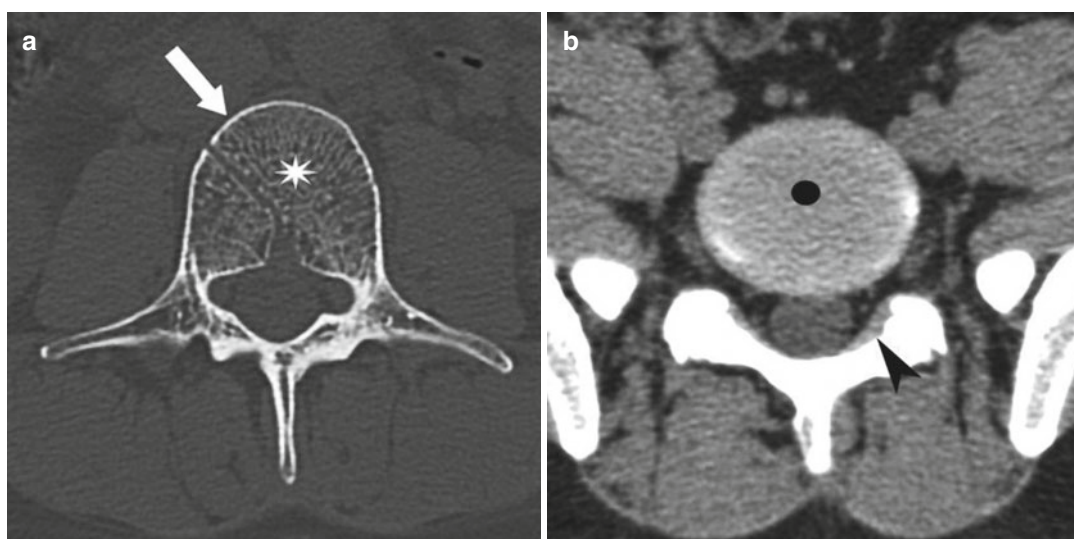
Lumbar rachis CT, with bone algorithm (a) and soft tissue window (b). The cortical bone (*arrow*), thin, dense, and regular, containing the less dense spongy
